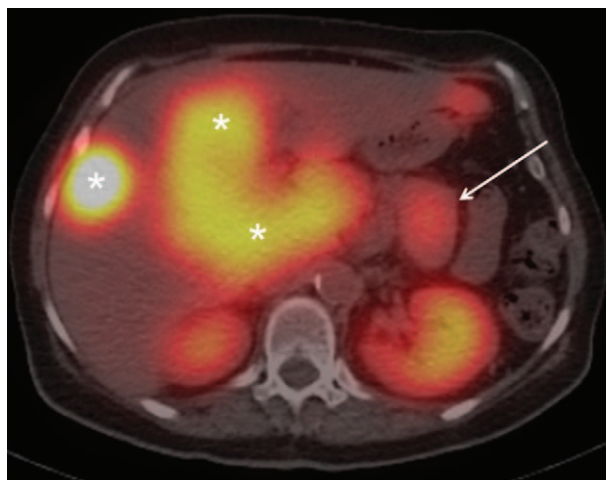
SPECT/CT with OctreoScan. Uptake in the pancreatic tail lesion consistent with primary neuroendocrine tumor (white arrow) and extensive octreotide avid masses in the liver corresponding to metastases (asterisks), indicating that the lesions over-expressed somatostatin receptors. CT = computed tomography, SPECT = Single Photon Emission Computed Tomography.
